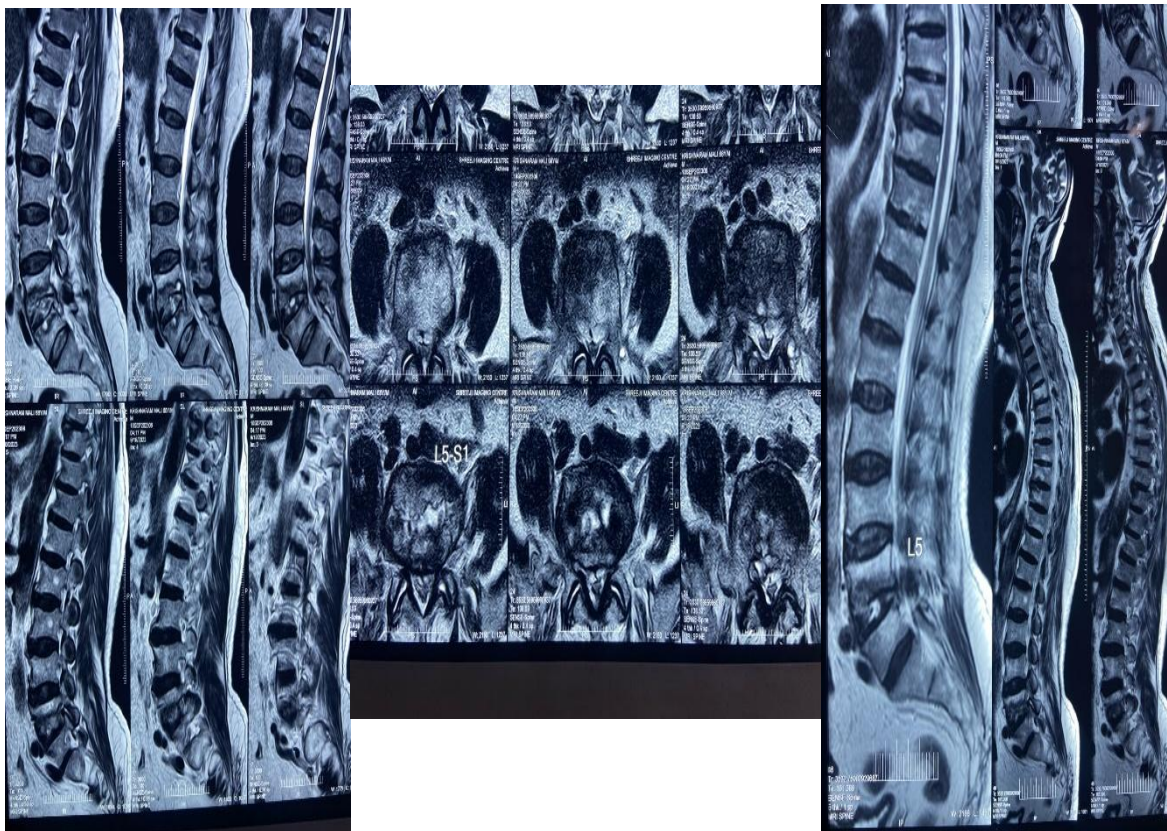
Preoperative MRI Scans
